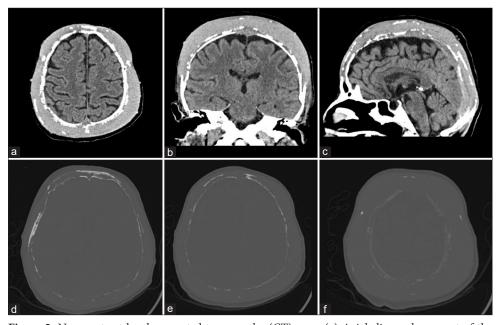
Non-contrast head computed tomography (CT) scan. (a) Axial slice, enlargement of the tumor with the effacement of the external table, the internal table is still somewhat preserved; (b and c) coronal slice and sagittal slice, respectively, showing a "helmet" form of the tumor; and (d-f) CT scan bone window, axial slices at various levels showing the destruction of the external table, with somewhat preserved internal table.
